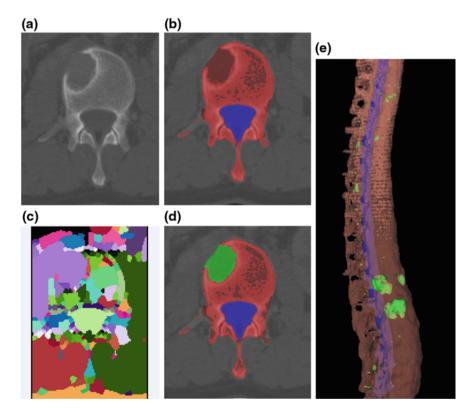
Lytic metastasis detection. a CT image; b spine segmentation; c watershed segmentation; d lesion segmentation; e lytic detection in 3D. *Green* lytic lesion detection; *Red* vertebra segmentation; *Blue* spinal canal
